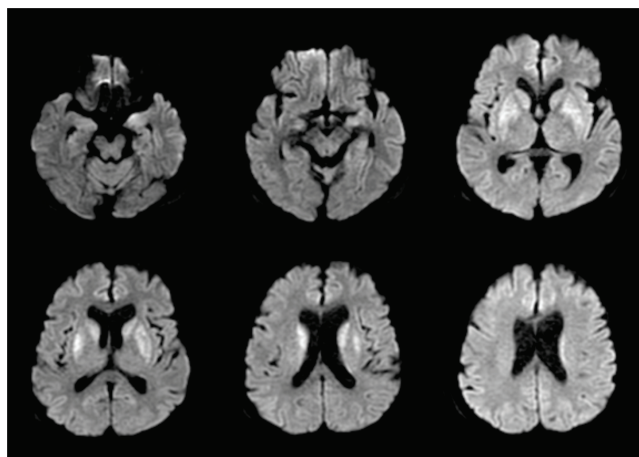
MRI image of west nile encephalitis showing diffusion restriction in bilateral caudate and putamen
